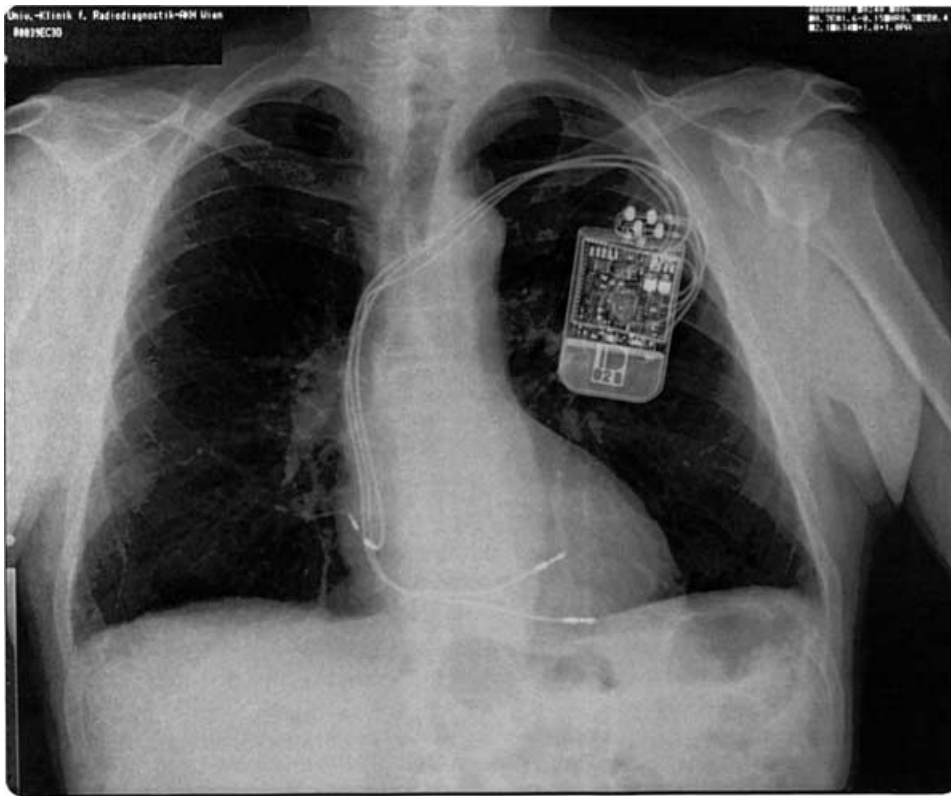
Chest radiograph in the anteroposterior view showing the positions of the three transvenous leads.
